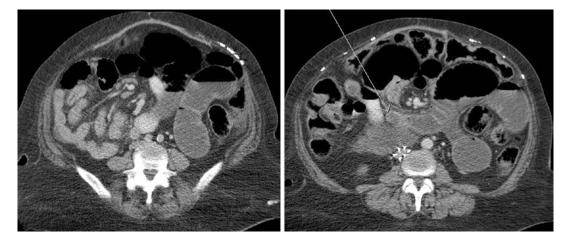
Computed tomography images of patient with small bowel obstruction. The first image demonstrates dilated and decompressed loops of small bowel. The arrow in the second image demonstrates a transition point
